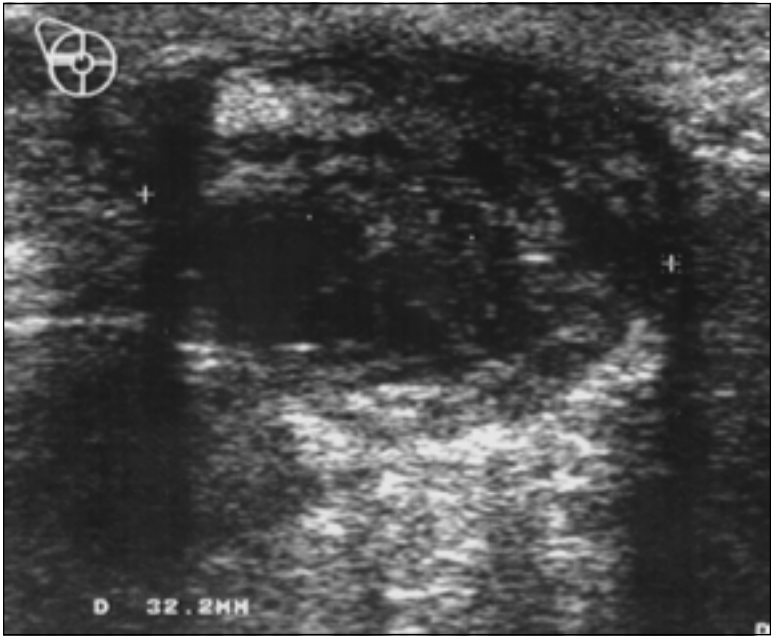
Ultrasound of a breast abscess appearing as a well-defined mass containing mixed echoes.
